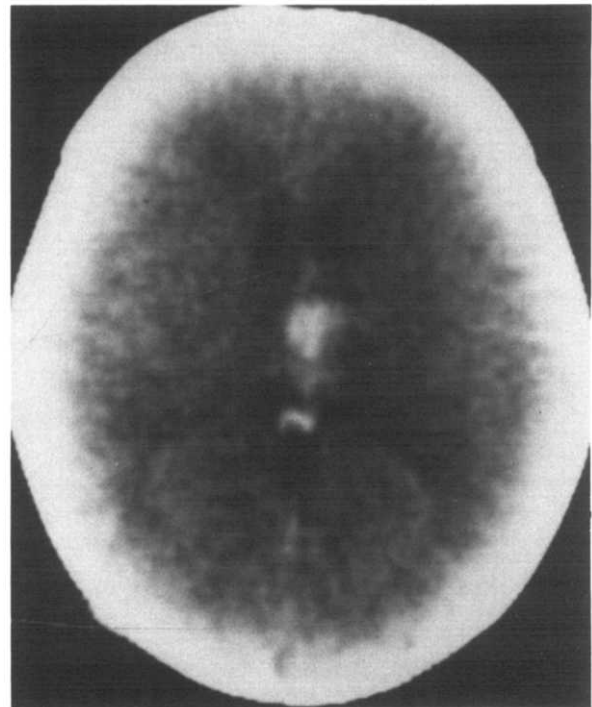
Cranial CT of Patient 1 demonstrating small left thalamic hemorrhage
